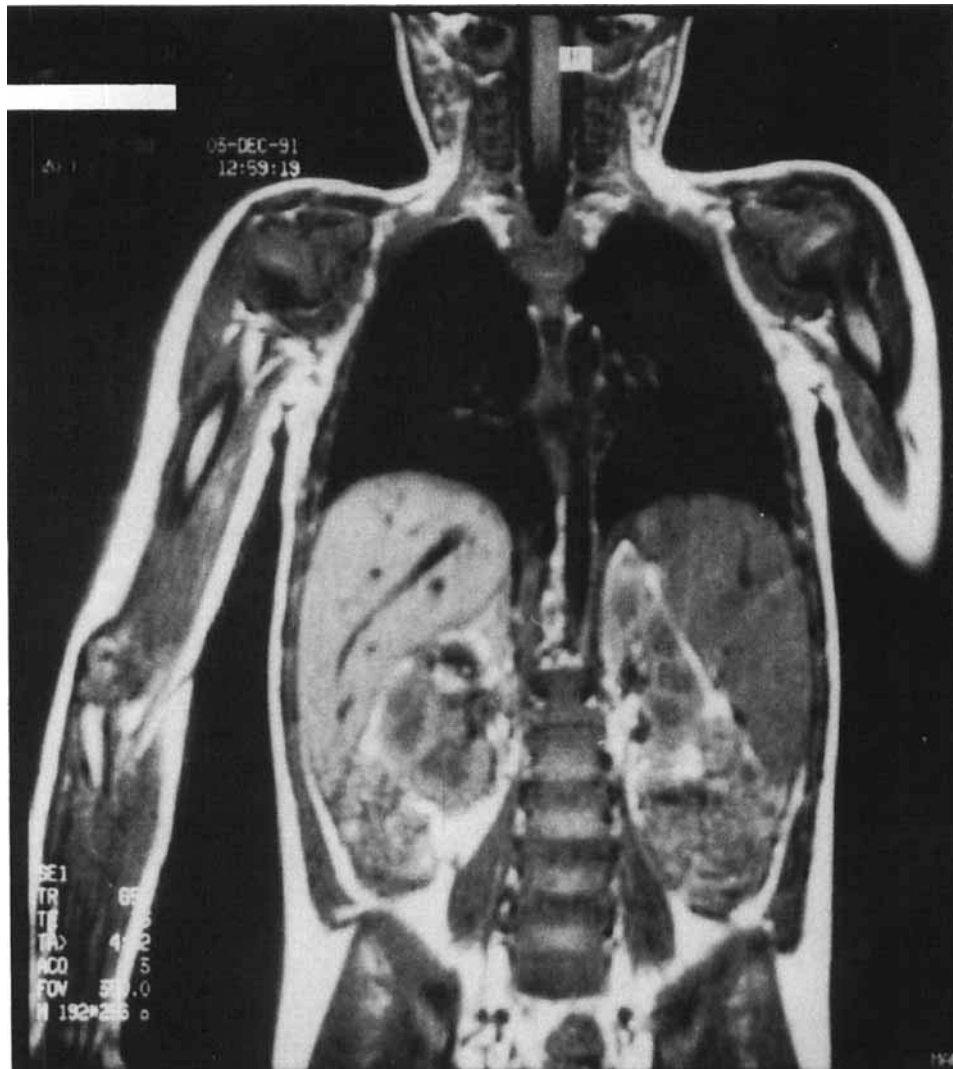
MRI (coronal T1w TR/TE 658/15 nex:3) showing inferior vena cava thrombosis after preoperative chemotherapy.
